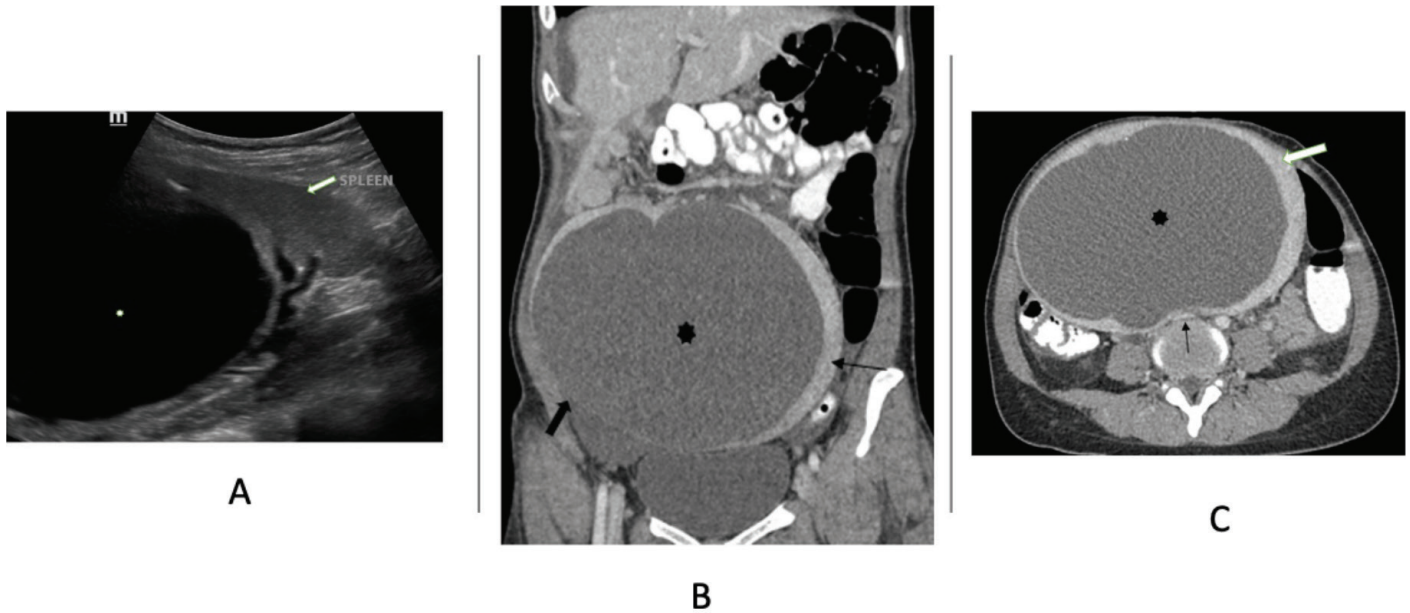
A) Ultrasound of the abdomen shows a large anechoic lesion (*) in keeping with the cyst occupying the spleen with remaining splenic parenchymal tissue (white arrow). B) Coronal view CT scan shows a large cyst (*) with the spleen (thin arrow). There is very thin remaining splenic parenchyma at the right lateral aspect with some areas showing focal discontinuity (big arrow) communicating with adjacent free fluid related to splenic rupture. C) Axial view CT scan shows spleen parenchymal tissue (big white arrow) at the lower abdomen with a large hypodense lesion (*) within in keeping with a cyst causing compression onto the left common iliac artery (thin black arrow). There is no solid component or septation within the cyst
